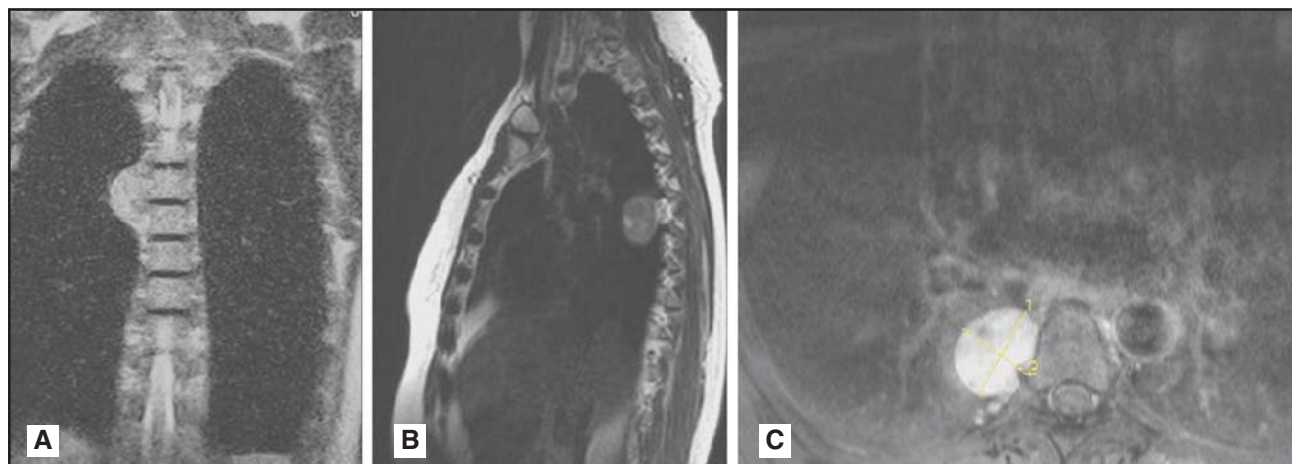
MRI of coronal (A), sagittal (B), and axial (C) views of thoracic spine of a 45-year-old woman with an incidental large 5- to 6-cm mass involving posterior mediastinum and paraspinal region at T4 level. Preoperative PET scan showed hypermetabolism in the lesion. Tumor was excised by standard transthoracic approach. The patient had an uneventful postoperative course and is doing well 7 months following surgery.
